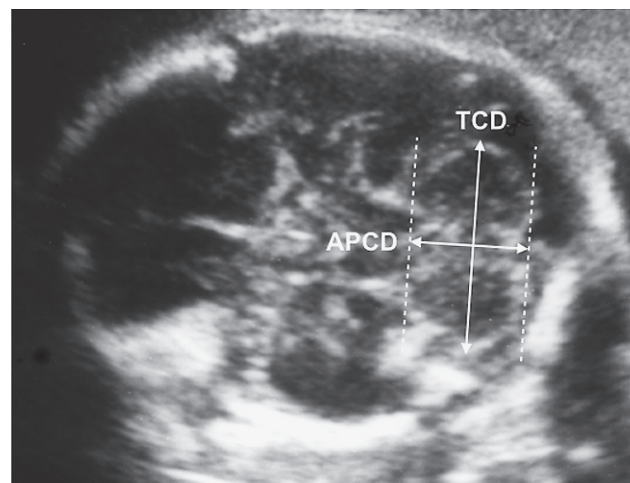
Axial ultrasound image at 30 weeks of gestation during measurement of the transverse cerebellar diameter (TCD) and anteroposterior cerebellar diameter (APCD). The APCD value was expressed as the mean value of the APCD diameters of the two hemispheres.
